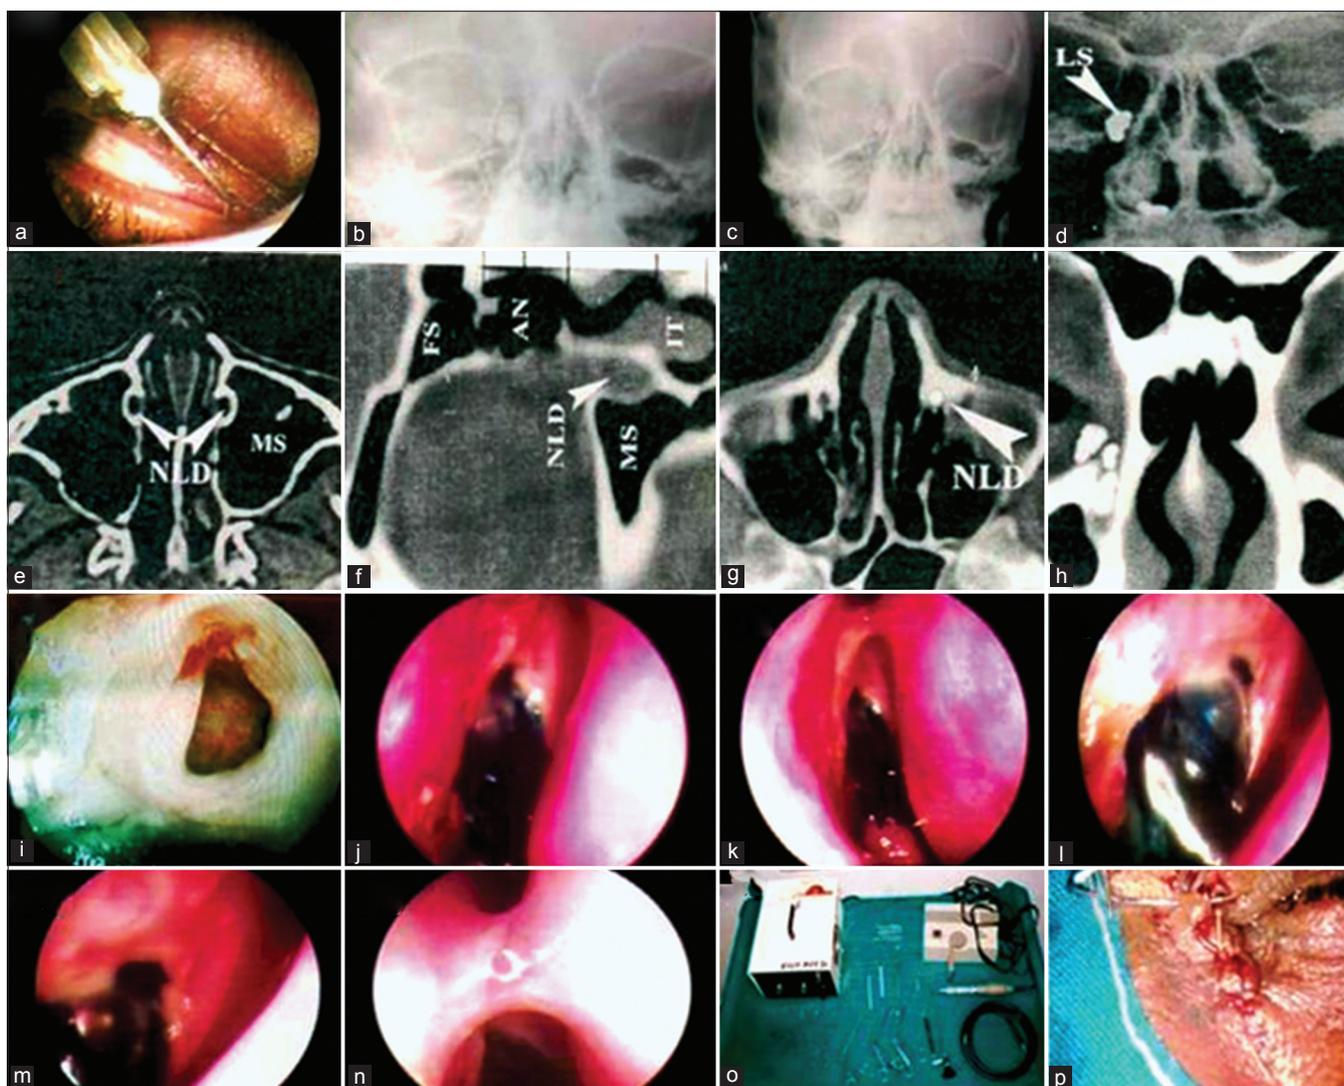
(a) Picture of syringing, (b,c) Dacryocystogram showing blocked NLD with dye in sac, (d) Dacryocystogram showing dye in the sac and nasal cavity, (e) CT showing NLD, (f) CT showing patent NLD on both sides (g) CT showing blocked NLD on one side (h) CT showing dye in the sac and NLD [i] Rhinostome at one week post-operative (j-m) Dye seen coming from the rhinostome 3 months post-operative (n) Syncychiac seen (o) Equipment used (p) External dacryocystorhinostomy post-operative showing the suture line
